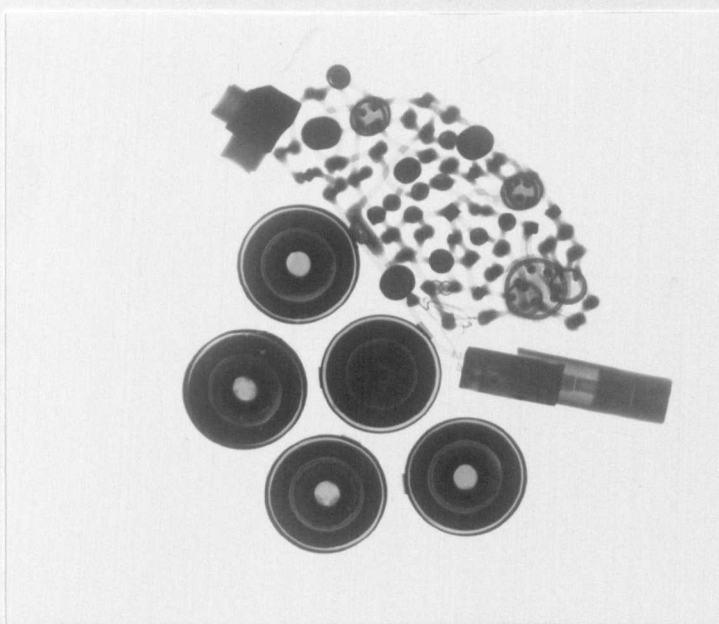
Radiographs of Medtronic generators showing mercury cells:
